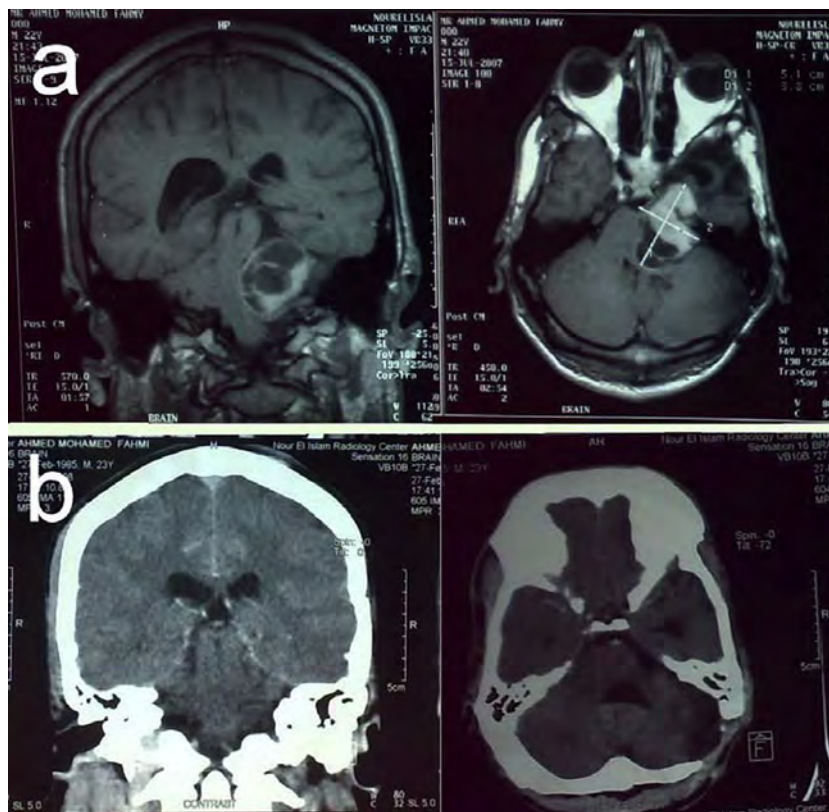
(a) Preoperative MRI for a case of medulloblastoma, (b) postoperative CT revealing the persistence of HC necessitating permanent V–P shunting.
